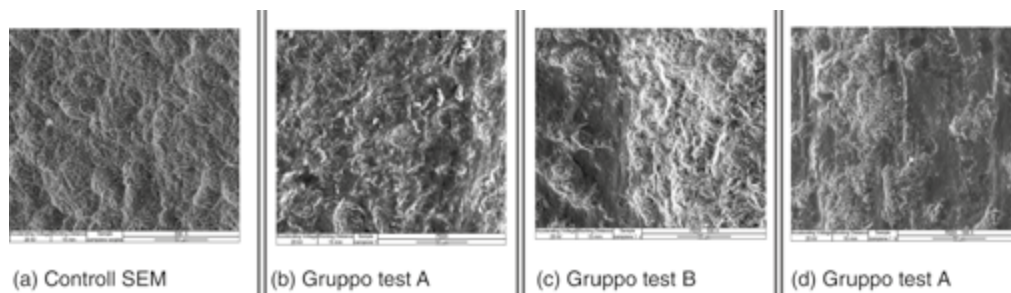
In the $\times 500$ scans instrumented with a peek insert (b–d), compared to the virgin control (a), the areas of marked sanding of the surface with a vertical and horizontal trend, due to the action of the Peek tip mounted on the ultrasonic handpiece, remain more visible between the normal implant texture of the implant. Gruppo test (B) versus Controlo SEM a $\times 500$
